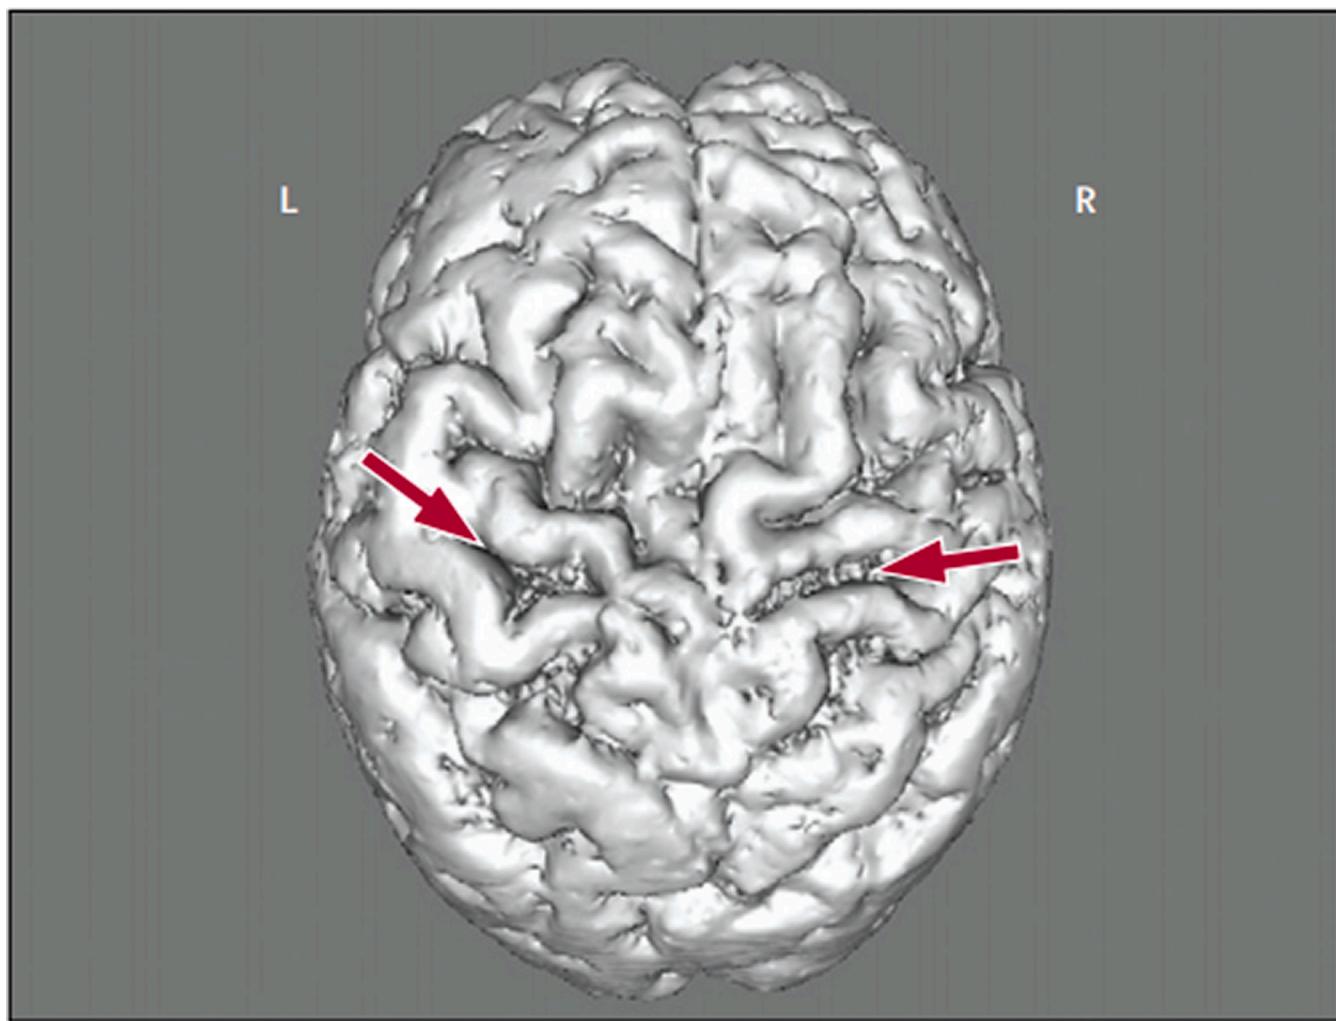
Top view of a patients' (primary lateral sclerosis) brain as observed by 3D MRI. Arrows indicate the broadened precentral sulci and atrophy in the adjacent gyri (motor strips). Macroscopic atrophy is a rare feature of typical ALS but projects the late stage of a corticomotoneuronal process that is hypothesized to be a characteristic of ALS.
